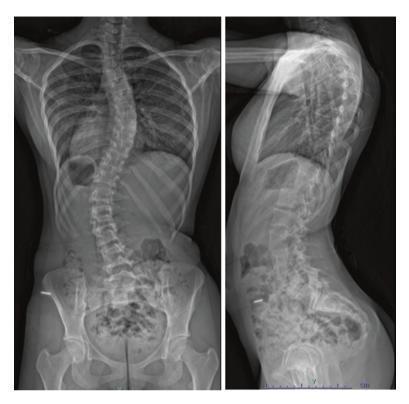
PA and lateral scoliosis preoperative radiographs
